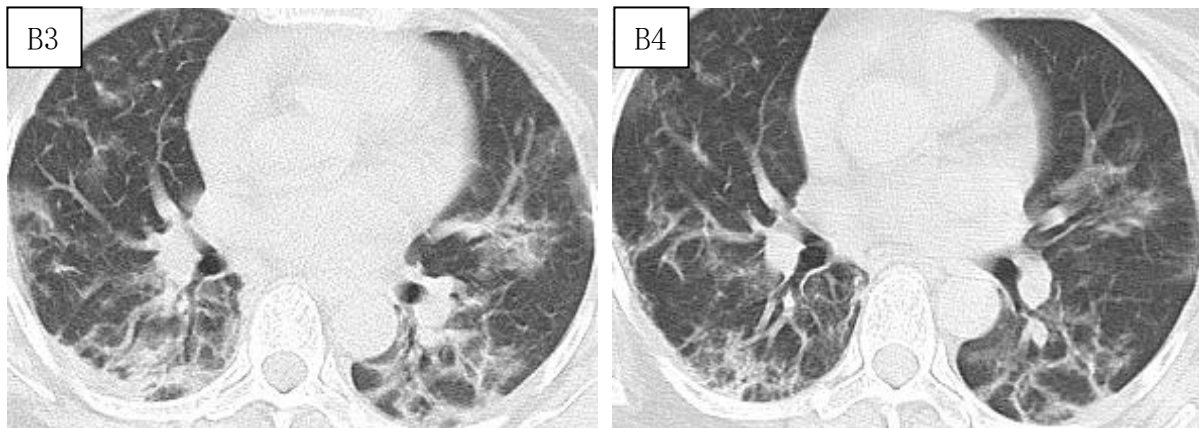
A1-A4 is a 43-year-old female input type second-generation NCP patient who was treated with fever (37.3°C), fatigue/tightness of breath. CT reexamination images were conducted on January 31, 2020.2.4, 2020.2.9, and February 13, 2020.respectively. The lesion area in FIG. A2 and A3 gradually changed from ground glass shadow to solid lesion. Dilated bronchus appeared in the lesion area, and the lesion area was reduced at the 4th CT reexamination, and small vacuoles appeared in the lesion area, mainly in the subpleural area.
